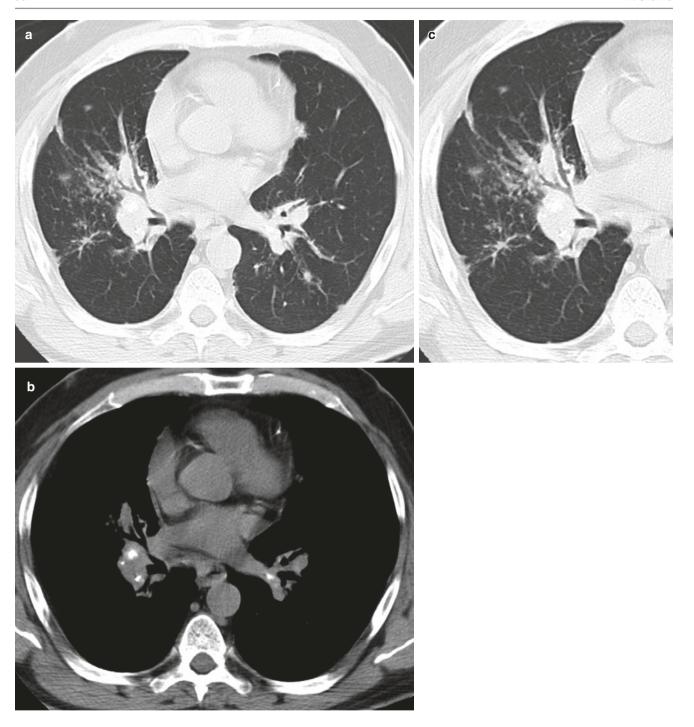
Bronchial dilatation in sarcoidosis. (a, b) Axial CT images show mild bronchial dilatation in right middle lobe with calcified bilateral hilar lymph nodes. (c) HRCT image shows "beaded" appearance of dilated bronchi presumably due to granulomas
